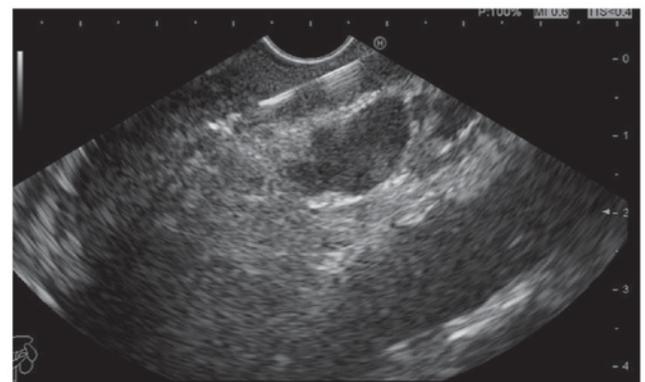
Puncture of pathological gastric wall guided by EUS-FNA. EUS-FNA, endoscopic ultrasound-guided fine-needle aspiration.
